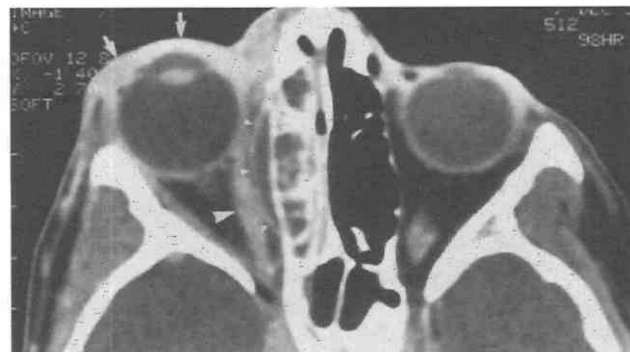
CT scan shows an extraconal subperiosteal abscess (small arrowhead). This is a complication of ethmoid sinusitis. A thickened, displaced medial rectus (large arrowhead) and preseptal soft tissue swelling (arrows) are seen.
